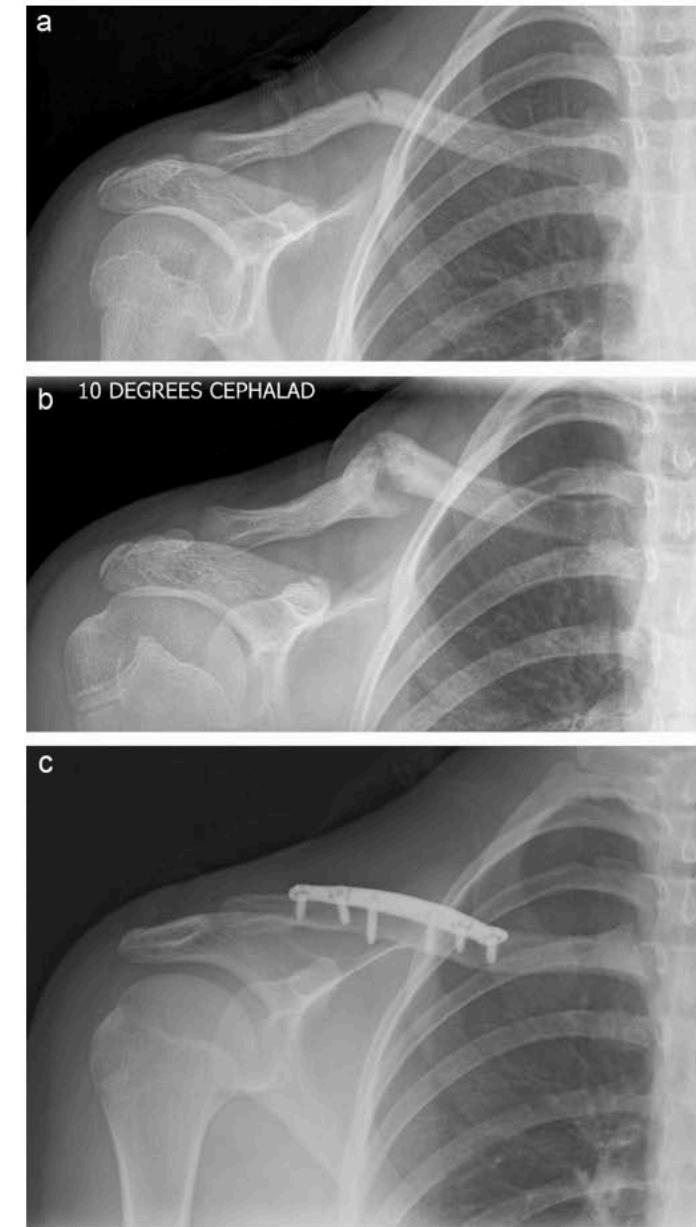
(A) A 12-year-old girl with a 33° angulated and minimally displaced clavicle fracture sustained while performing karate. (B) At 7 months after injury, the patient was diagnosed with a nonunion. (C) Final radiograph taken 18 months after nonunion repair with local bone graft demonstrating a healed clavicle.
